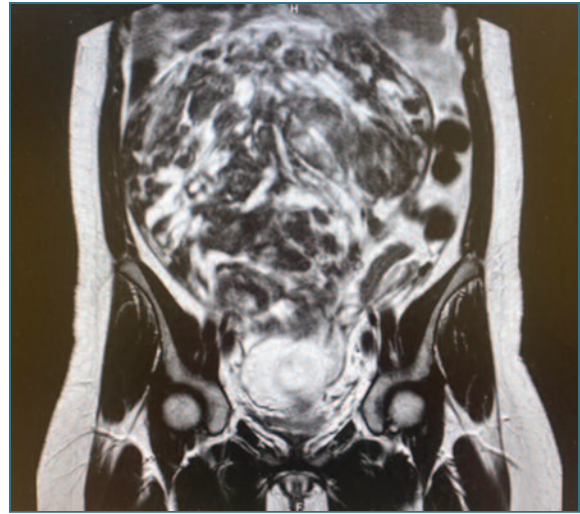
MRI images of the fibroid at 10 weeks of pregnancy.
